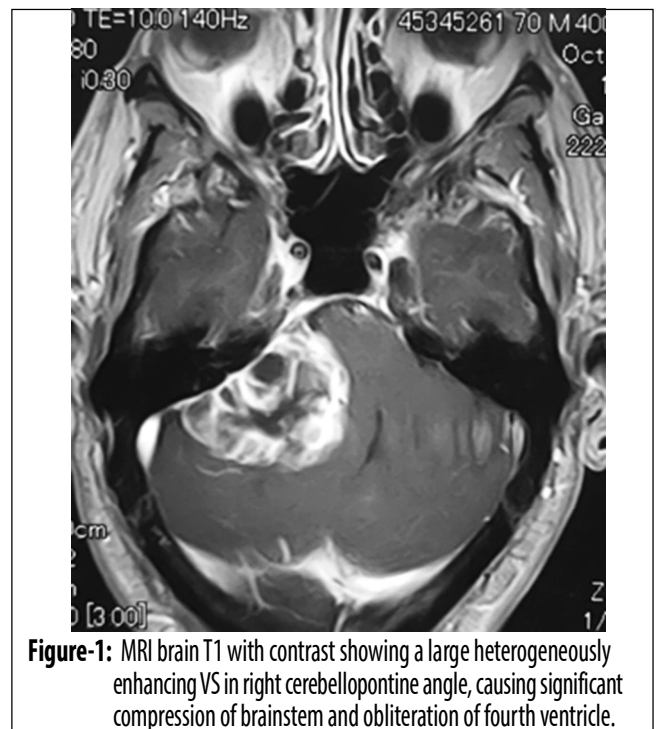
MRI brain T1 with contrast showing a large heterogeneously enhancing VS in right cerebellopontine angle, causing significant compression of brainstem and obliteration of fourth ventricle.
